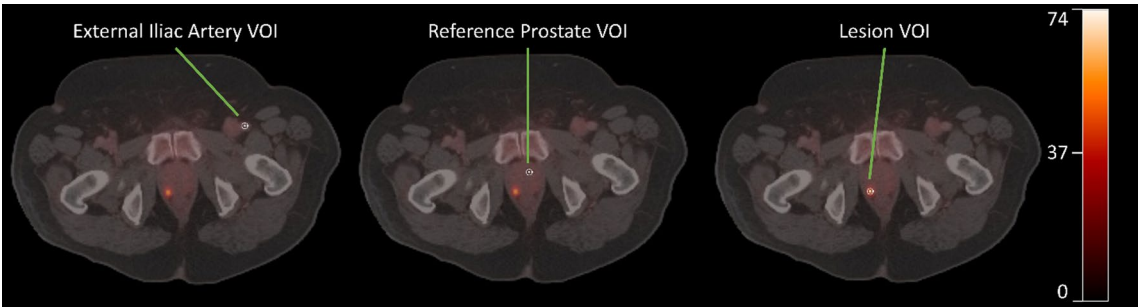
10 mm spherical VOI placements for artery (left), normal prostate tissue (middle), and lesion (right). An early bolus phase image was used to locate the external iliac artery. All three displayed images are 40–55 min PET frames overlaid with CT. Scale bar is in units of kBq/mL
